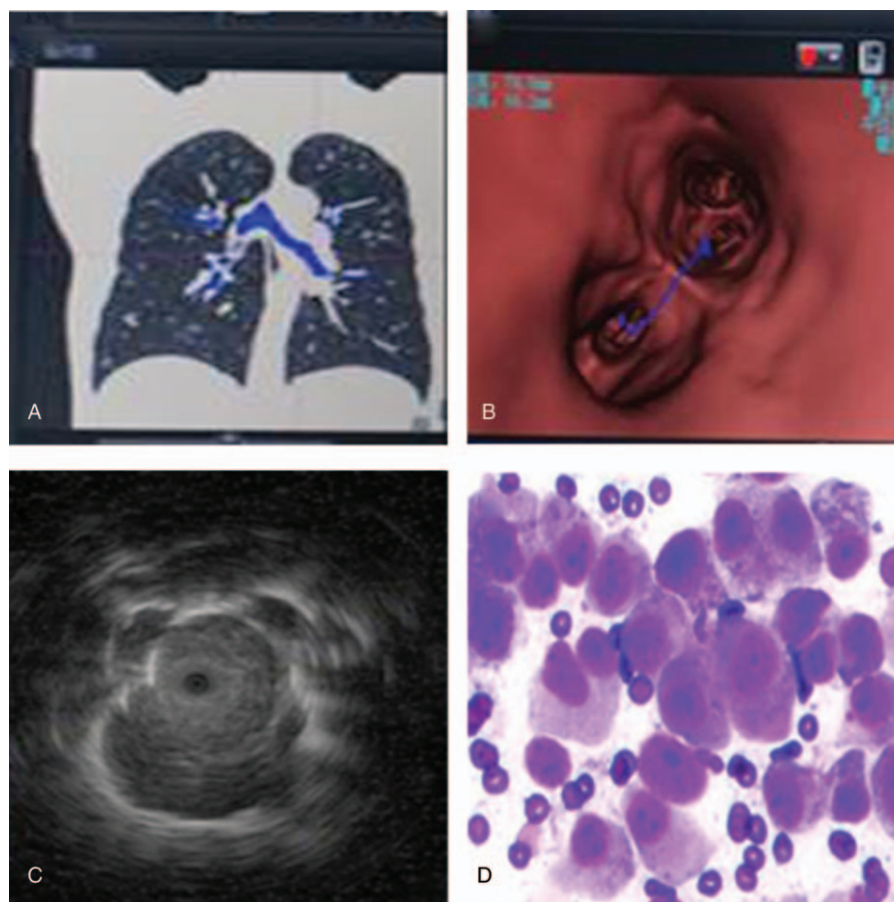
(A) The coronal position setting navigation path. (B) VBN demonstrated a precise route to the peripheral nodule. (C) EBUS showed a low-echoic nodule surrounded by a highly reflective interface produced between the aerated lung and the lesion. (D) Adenocarcinoma of the lung was diagnosed from EBUS-guided TBLB. EBUS=endobronchial ultrasound, TBLB=transbronchial lung biopsy, VBN=virtual bronchoscopic navigation.
